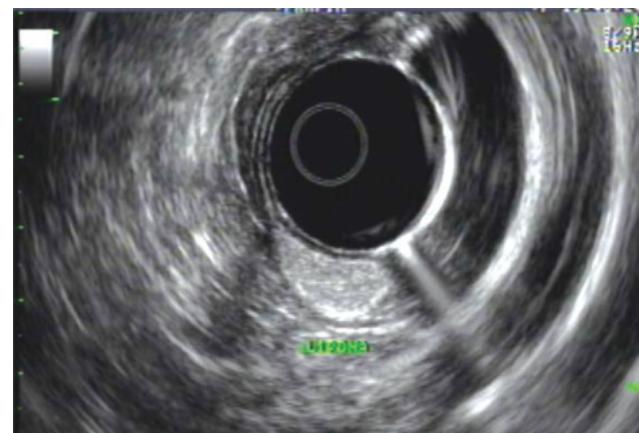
Demonstrating a well demarcated, hyperechoic, arising from the third layer (radial endoscopic ultrasonoscope (Olympus, Tokyo)).
